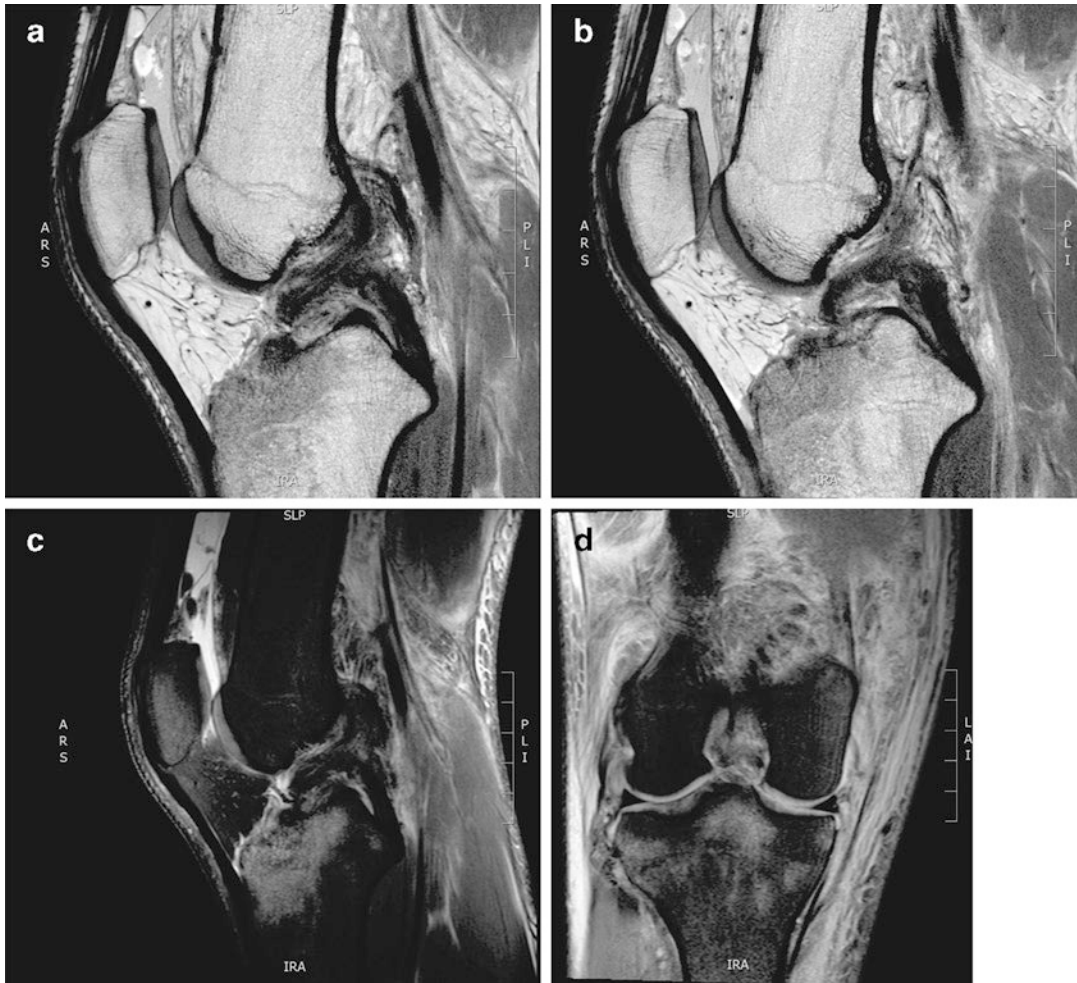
(a, b) T1 sagittal MRI knee (c) T2 sagittal MRI knee (d) T2 coronal MRI knee
